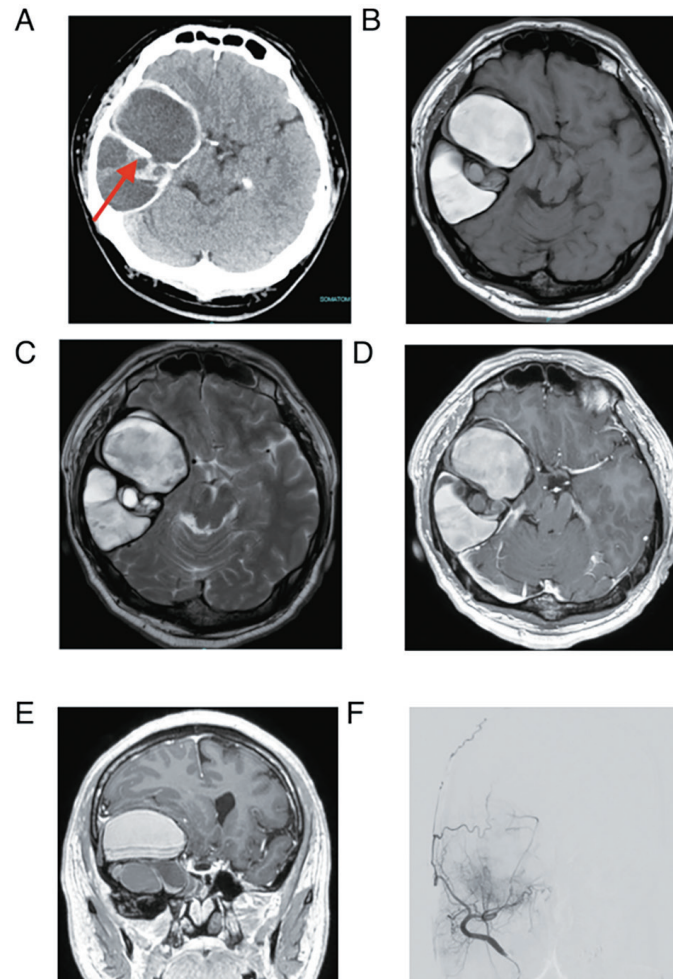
A; Axial computed tomography scans indicate the extradural tumor compressing cerebral parenchyma in the right middle cranial fossa. There are bony outer shells and multiple internal septa (arrow). B-E; Preoperative magnetic resonance imaging showing the lesion. T1-weighted scans (B) depict expansile, extra-axial lesions in the right medial cranial fossa. T2-weighted scans (C) and T1-weighted MR images with contrast enhancement (D, axial image; E, coronal image) showed fluid-fluid interfaces within cystic lesions of the tumor. F; The right external carotid angiogram revealed the tumor blush through the right internal maxillary arteries.
